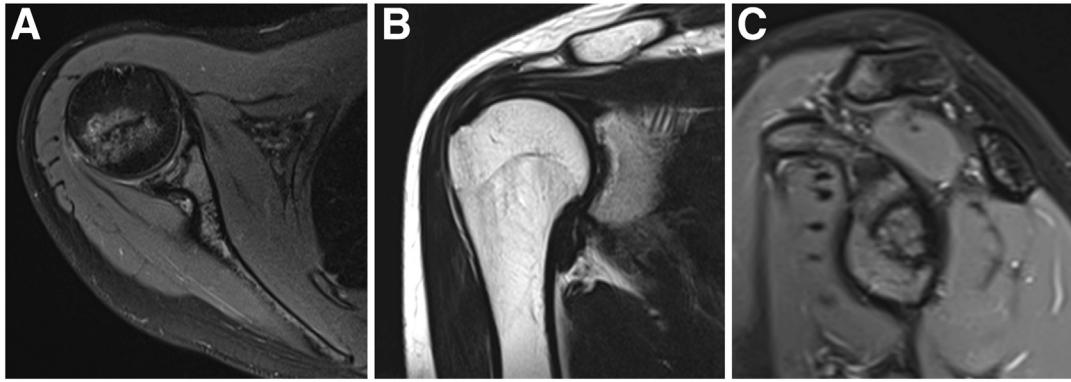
Preoperative magnetic resonance imaging: axial PD-TSE-FS (A), coronal T2-TSE (B), and sagittal PD-TSE-FS (C) plane of the right shoulder. The glenoid OCD lesion appears as a well-defined area of altered intensity in the chondral and subchondral bone. In this young female patient, 22 years old, professional volleyballer, the OCD lesion is an area of 1.1×1.3 cm in the posterosuperior surface of the glenoid. (FS, fat-suppressed; OCD, osteochondrosis dissecans; PD, proton density; TSE, turbo spin echo.)
